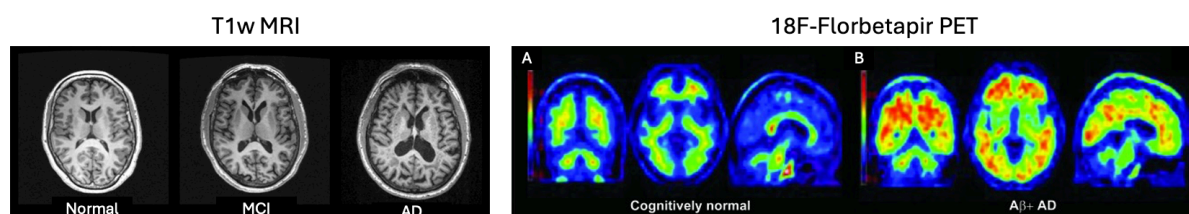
(Left) T1w MRI axial slices show reduced gray matter volume in an AD patient compared to a healthy control, with intermediate loss in a mild cognitive impairment (MCI) patient. Obtained from [25]. (Right) 18F-Florbetapir PET shows minimal $A\beta$ deposition in a normal subject (A) and significant $A\beta$ accumulation in an AD patient (B). Obtained from [26].
